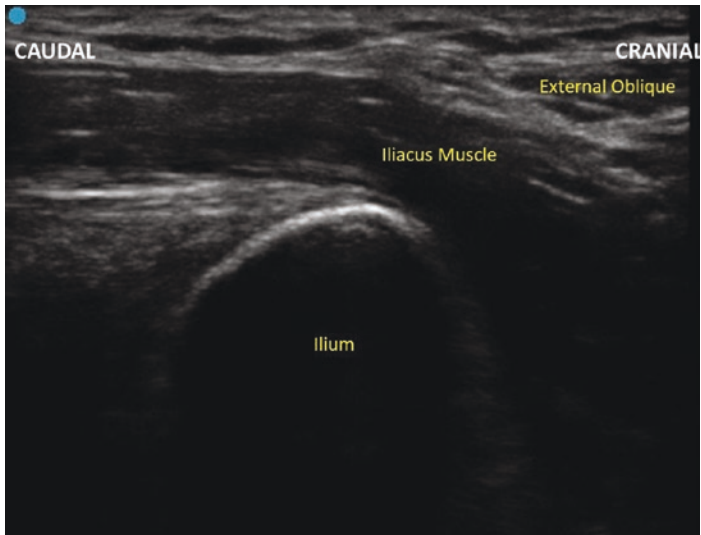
Suprainguinal fascia iliaca ultrasound
